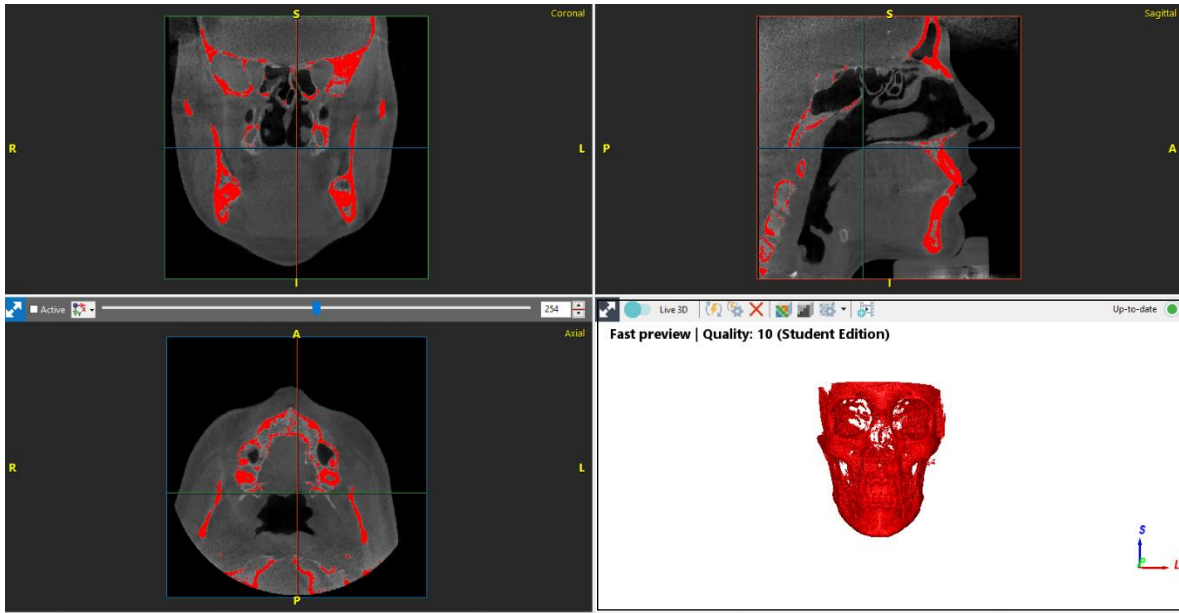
Mask creation from a skull CT scan in Simpleware Scan IP.
